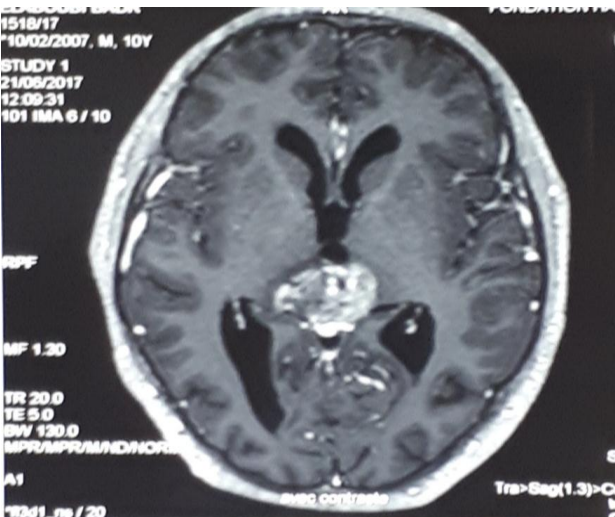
A brain CT scan showing a pineal region tumor.
